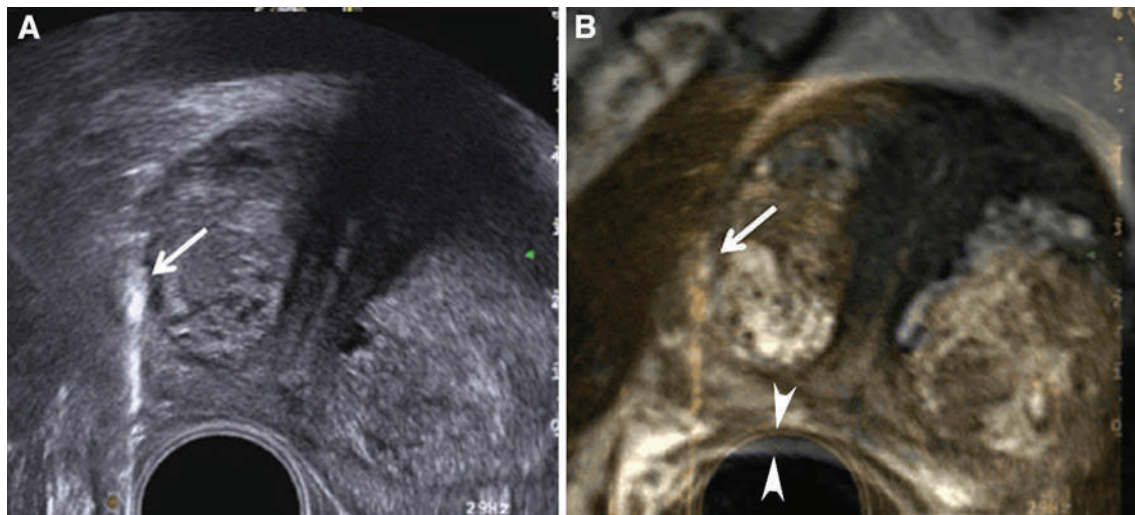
Sensor-based registration. Guiding phase of the biopsy. Same patient as Fig. 3a. The needle tract (*arrow*), visible on TRUS (A) can be seen on the overlaid MR image
